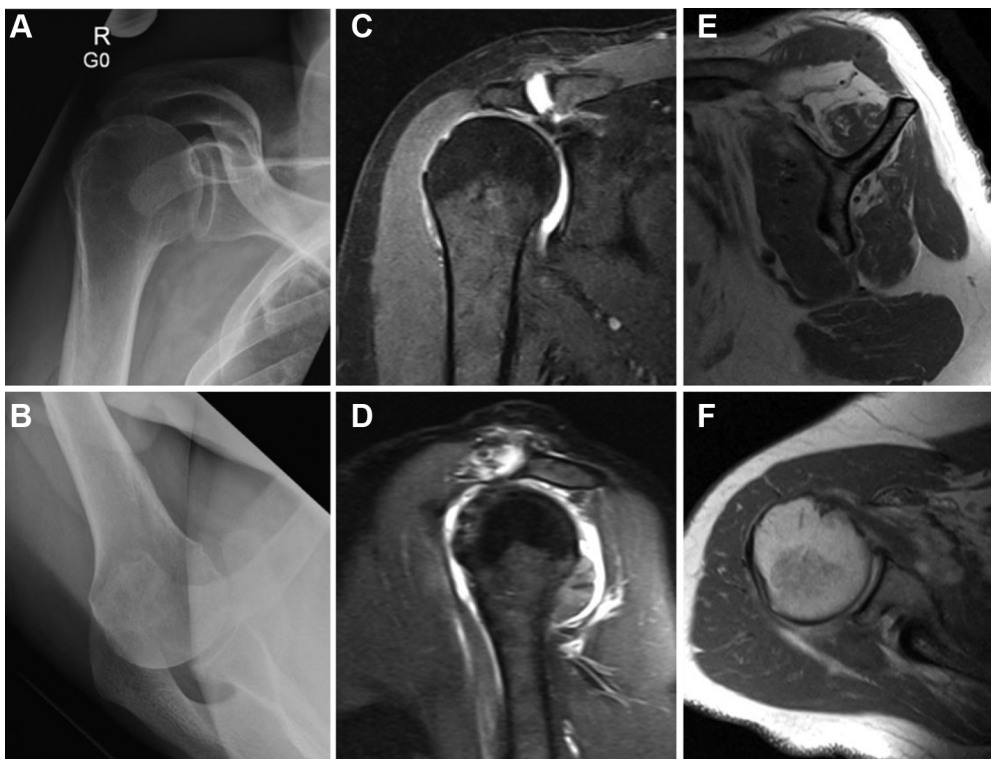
Radiologic imaging on first consultation. (A and B) anteroposterior- and axillary-view x-rays. (C–F) MRI showing the massive irreparable rotator cuff tear with posterosuperior retraction to the glenoid and atrophy and fatty infiltration of the supra- and infraspinatus.
